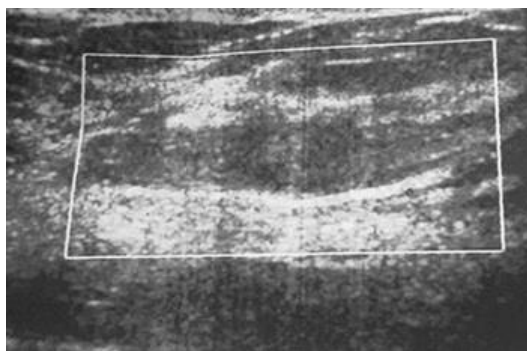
Ultrasound image of ductal dilatation with an echogenic component
